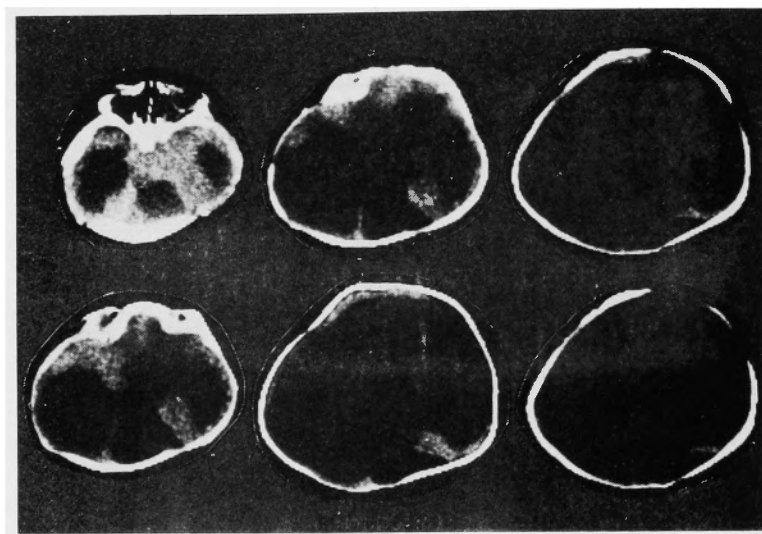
Case 1. CT scan showing a large monoventricle. Note the CSF-density space in the midoccipital region. No falx can be seen.
